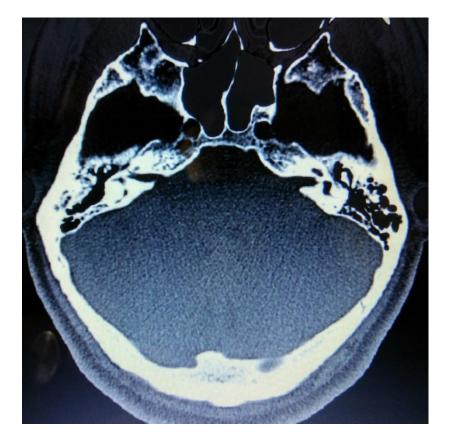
HRCT TEMPORAL BONE - AXIAL CUT
